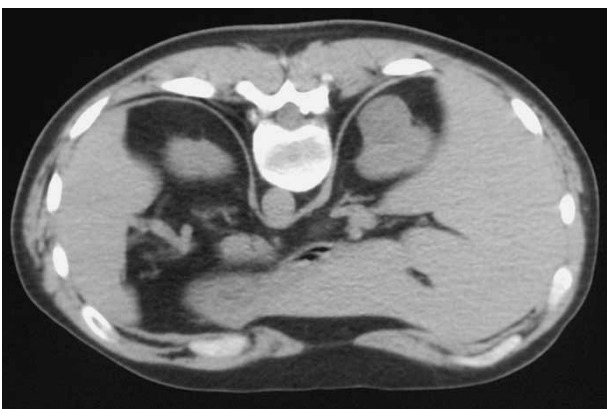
A CT of the abdomen showing an isolated abnormality of a well-circumscribed right renal mass.
